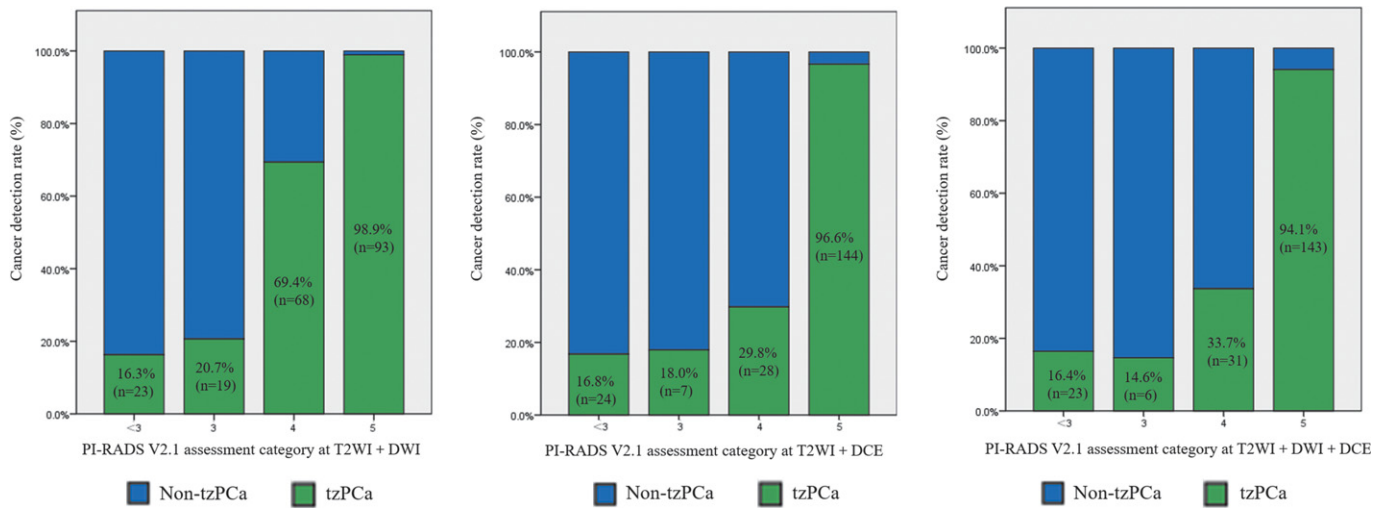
Histograms showing cancer detection rates of tzPCa based on the T2-weighted imaging (T2WI) + diffusion-weighted imaging (DWI), T2WI + dynamic contrast-enhancement (DCE), and T2WI + DWI + DCE.
